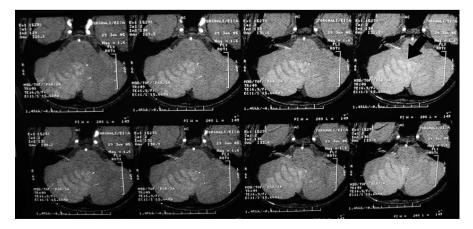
T2 weighted axial brain MRI at the level of medulla; there is a right posterior inferior cerebellar artery territory infarct (arrow).
